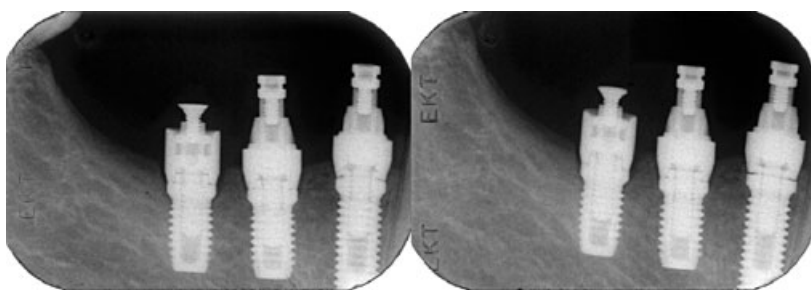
Small gaps between abutment and implant pillar (most mesial implant) may go unnoticed in radiographs taken with less than perfect geometry (left image).
